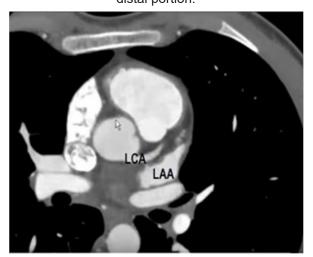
Computed tomography of the heart. The image shows the left atrial appendage and its close relationship with the left coronary artery (LCA) as it starts from the ascendant aorta at the level of left coronary cusp.
